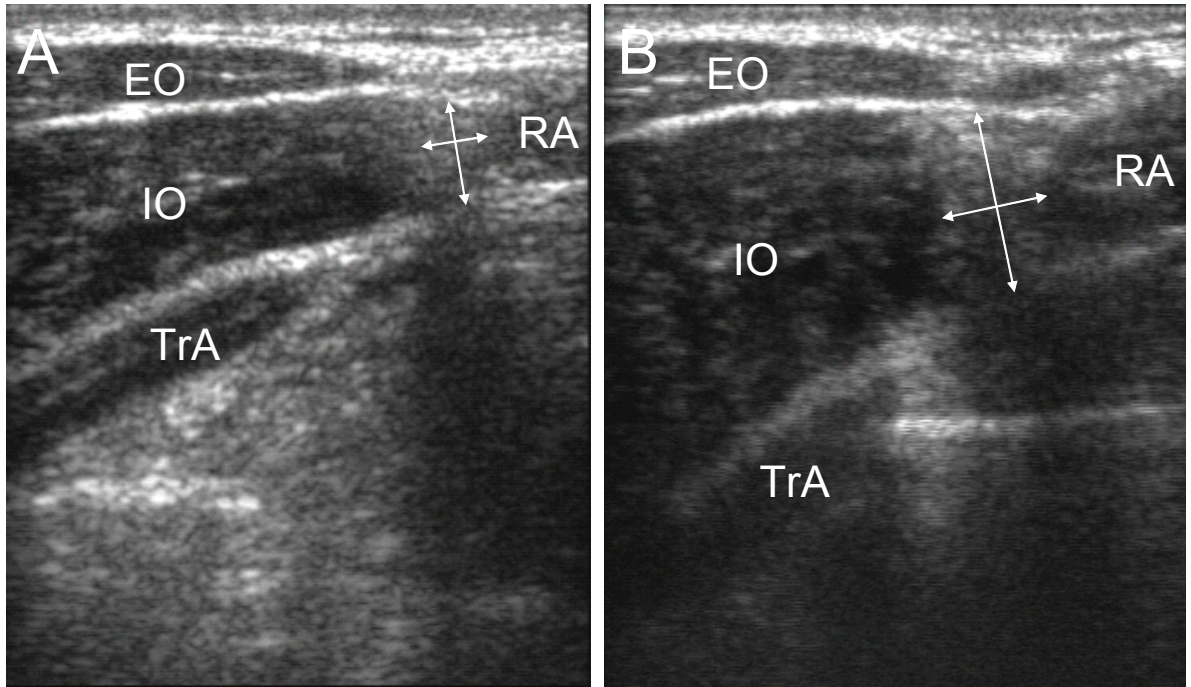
Example of an ultrasound image, taken transverse through the abdomen, of the IO aponeurosis captured at relaxation (A) and 100% of maximum contraction (B). The more vertically oriented arrows indicate the measure of aponeurosis thickness; the more horizontally oriented arrows indicate the measure of aponeurosis length.
